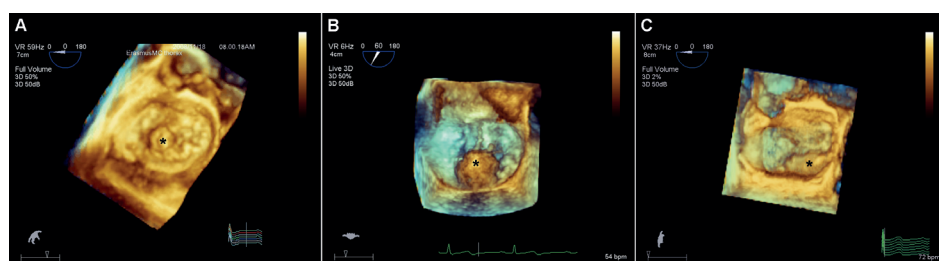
Three-dimensional echocardiographic surgical view of mitral prolapse extent: small P2 prolapse (A), broad P2 prolapse (B) and P2-P3 prolapse (C). The sites of prolapse are indicated with arrowheads.
